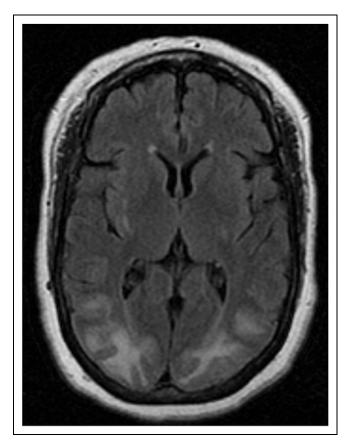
Symmetrical posterior edema on MRI T2 FLAIR images characteristic of posterior reversible encephalopathy syndrome (PRES) in a hypertensive pregnant woman who presented with visual changes (patches in her vision).
